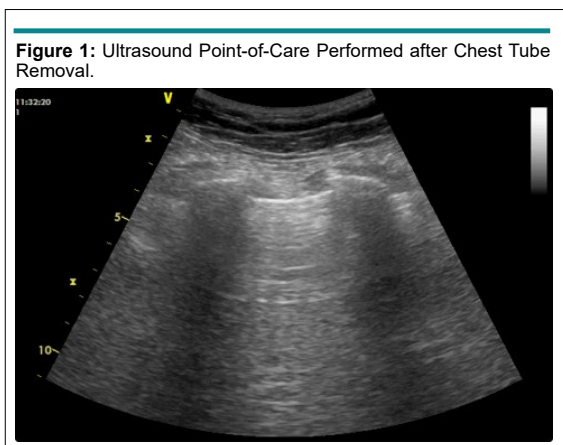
Ultrasound Point-of-Care Performed after Chest Tube Removal.
